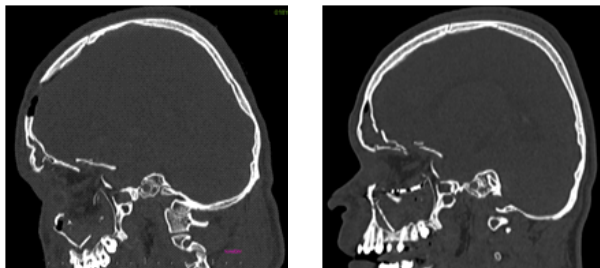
pre op and post op CT sagittal view with titanium mesh for orbital floor reconstruction
